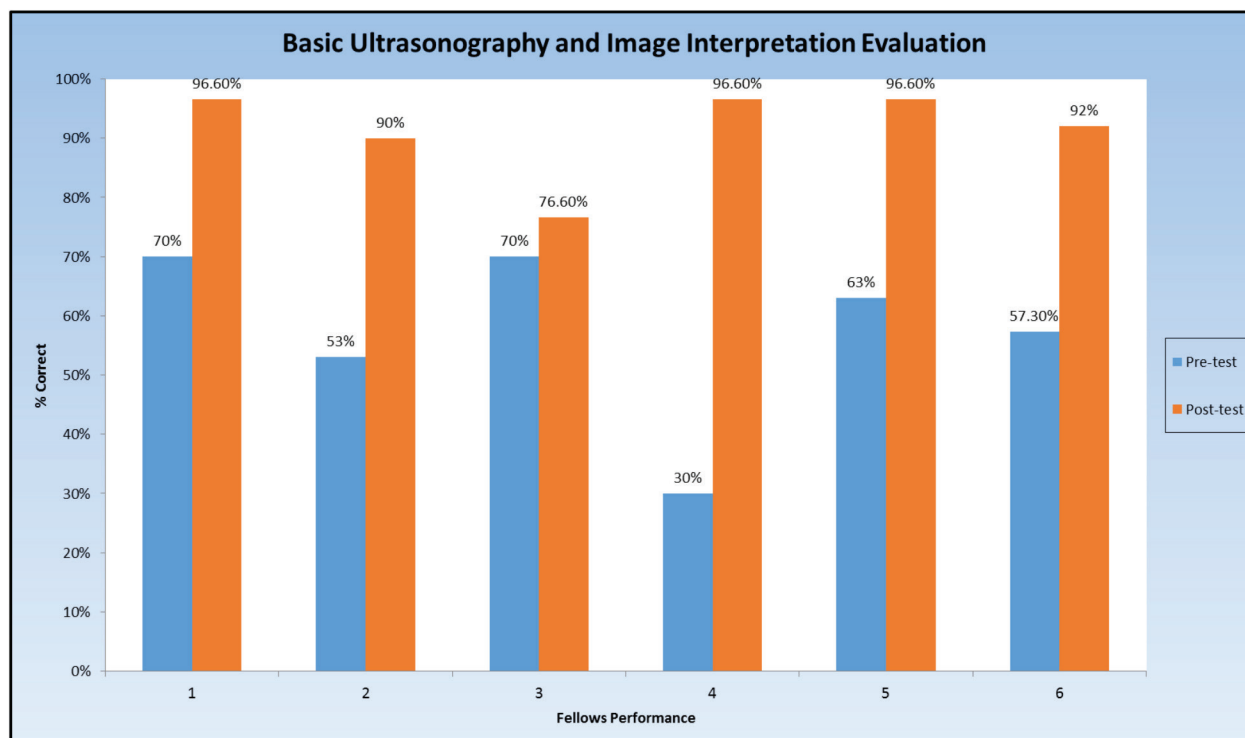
FELLOW PERFORMANCE ON BASIC ULTRASONOGRAPHY AND IMAGE INTERPRETATION DOMAINS
